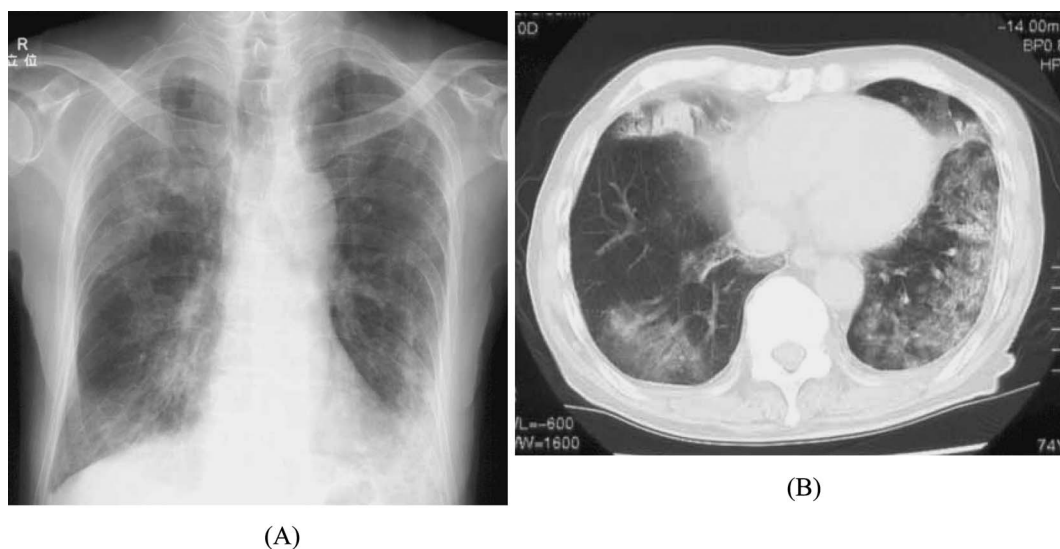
[Chest radiographic findings on admission]. (A) Chest radiography on admission showing diffuse multiple consolidation in bilateral lung fields. (B) Chest CT on admission showing bilateral consolidation in multiple lobes.
